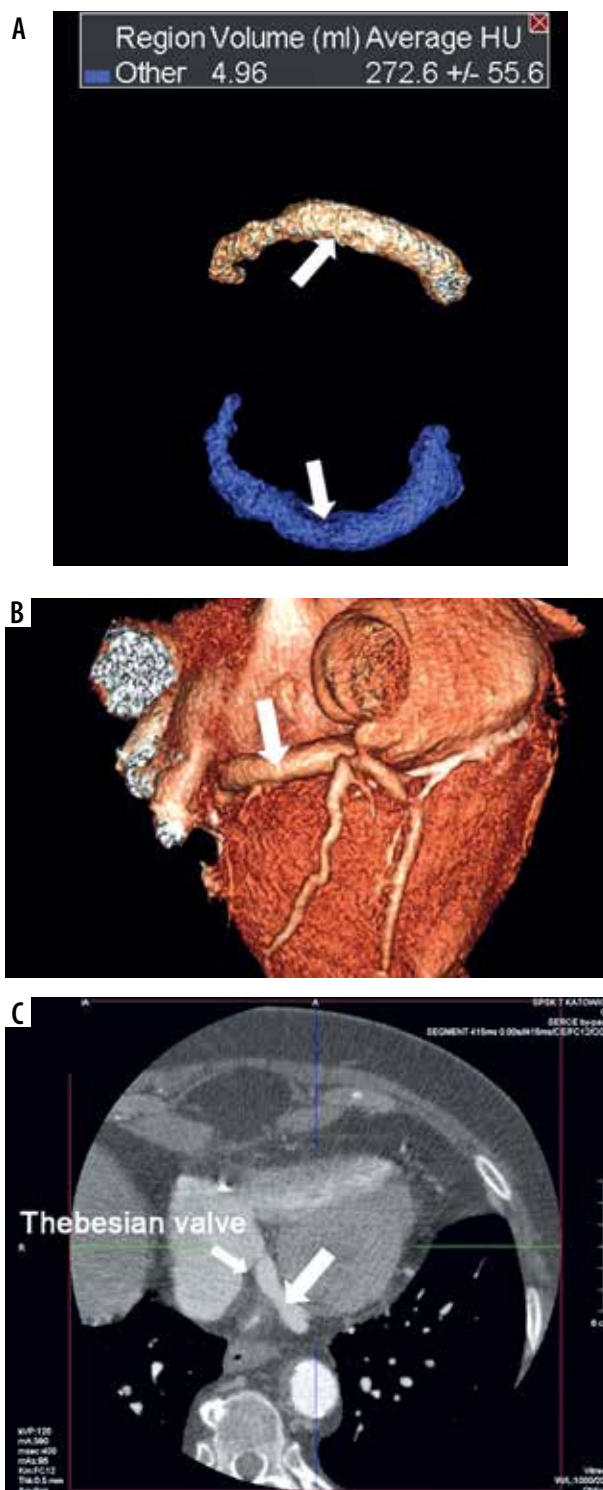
Example of visualisation and measurement of the volume of the coronary sinus in cardiac computed tomography
